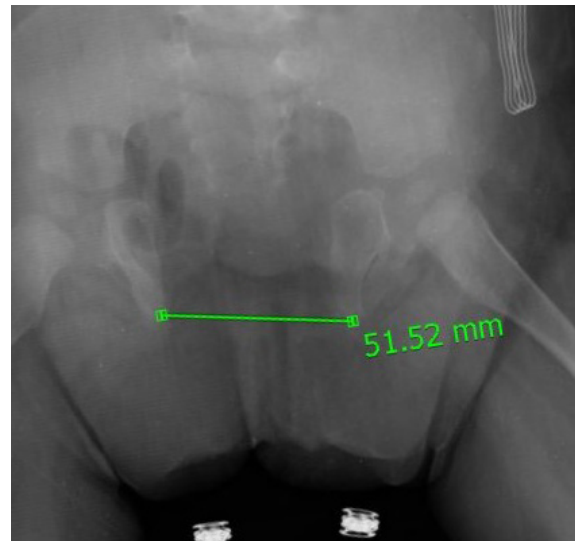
Preoperative anteroposterior X-ray graphy.
